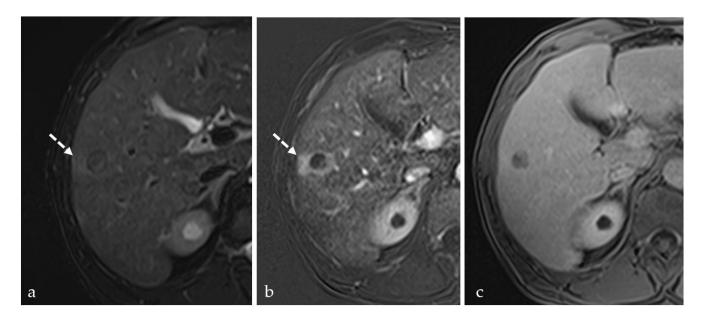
MRI scan: (a)—T2 weighted with fat suppression; (b)—subtraction; (c)—T1 weighted with fat suppression after contrast injection, in the portal venous phase. Transient hyperemia (dotted arrow in (a) and (b)) surrounding an HCC tumor treated using DEB-TACE. The hyperemia appears as a halo with hazy contour and discrete high signal intensity on T2 WI, arterial phase wash-in, but without portal venous phase wash-out (differentiating it from tumor tissue).
